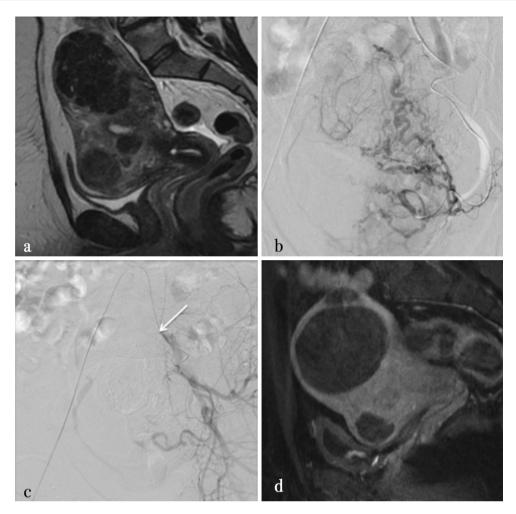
42-year-old woman with uterine fibroids treated with embolization; a before treatment, multiple intramural hypointense fibroids of the uterus are identified at sagittal T2-weighted image; b hypervascularization of the fibromatous uterus demonstrated thanks to a selective injection of the *left* uterine artery; c selective injection
